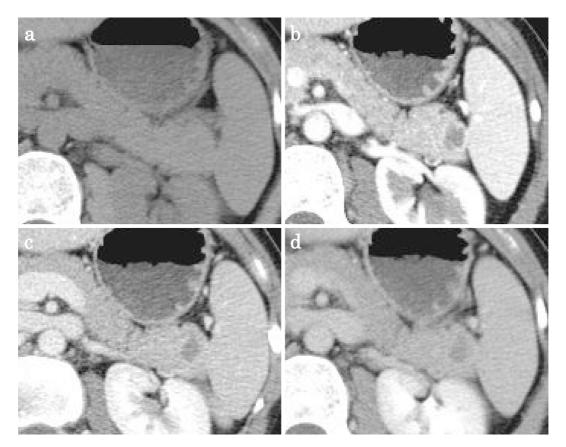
Dynamic computed tomography reveal a mass measuring 3 cm in size in the pancreatic tail with a cystic lesion and a solid component located on the periphery that is enhanced in the arterial phase. The densities of the solid component and spleen are very similar (a: plain, b: arterial phase, c: portal phase, d: delayed phase).
